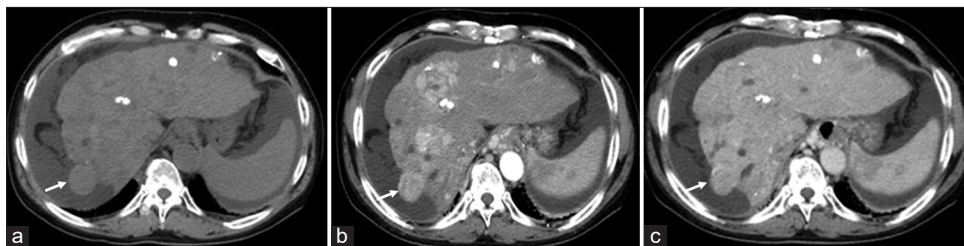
A 60s male patient with multifocal hepatocellular carcinoma (HCC) who was admitted to our hospital for treatment of HCCs. Abdominal dynamic contrast-enhanced computed tomography was performed before the drug-eluting beads transarterial chemoembolization (DEB-TACE). (a) The pre-contrast image shows multifocal low-density tumors suggestive of HCCs in the right and left lobes of the liver (white arrows). (b) The arterial phase shows contrast enhancement of the tumors, one of which protruded prominently outside the liver in segment 8 (white arrows). (c) The portal venous phase shows washout compared to the arterial phase (white arrows).
